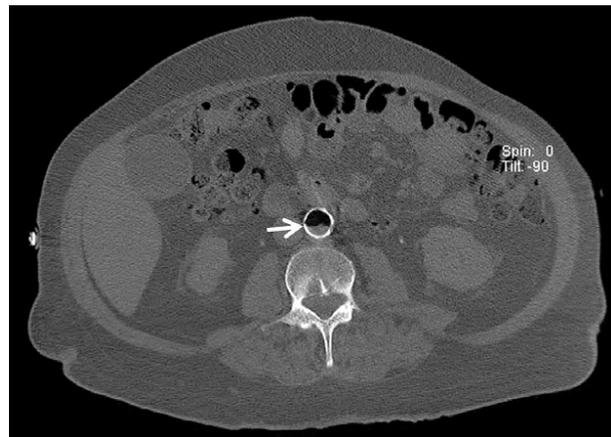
Axial CO₂CTA imaging demonstrating layering of CO₂ gas and blood within the aorta (white arrow).
